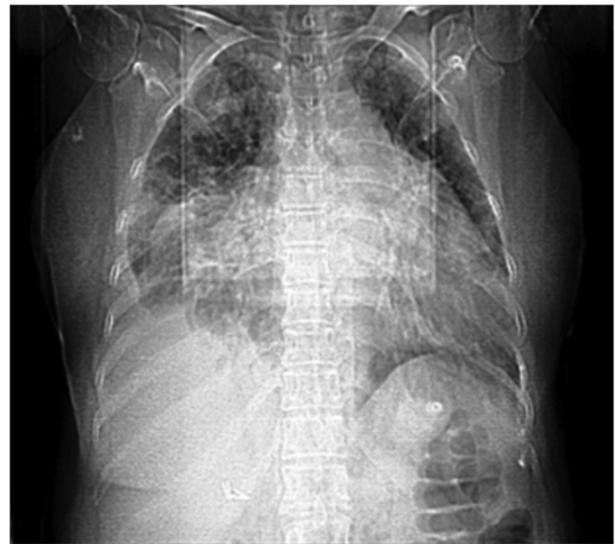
Chest X-Ray Demonstrating Increase of Cardio Thoracic Ratio and Costophrenic Angle Blunting
